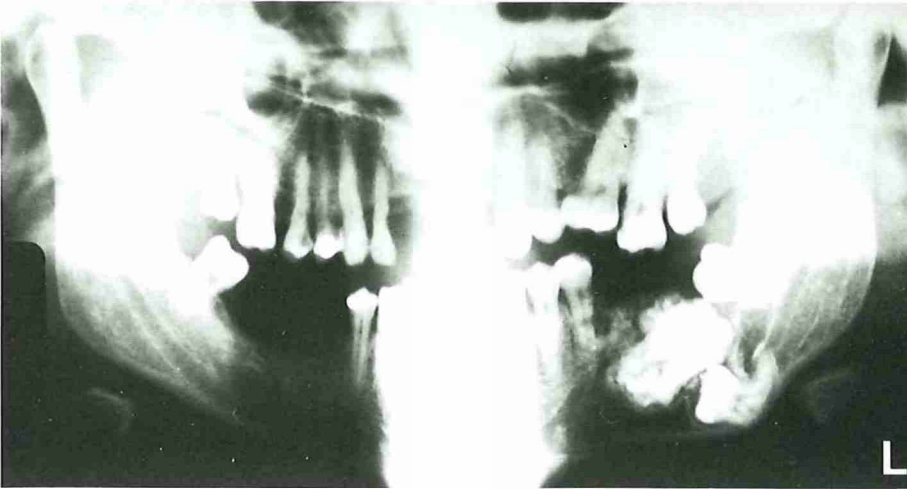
Orthopantomogram of a 46-year-old male showing impaction of the mandibular left second molar. A complex odontome was found as a possible physical barrier in the eruption path.
